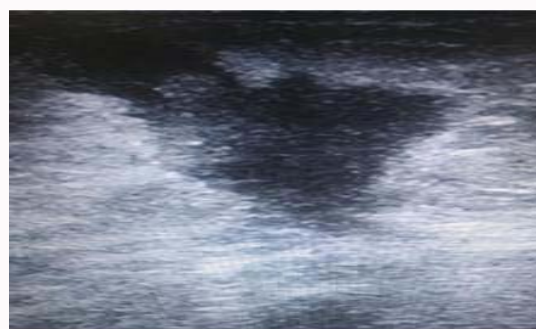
Pre-laser sonography picture of Ca breast hypoechoic area with speculated margins.
